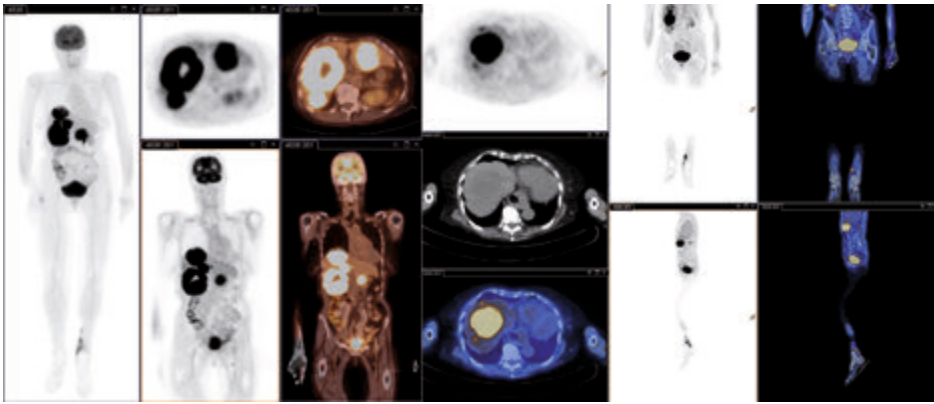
Whole-body FDG PET/CT patient 2 (Table 4.2)
